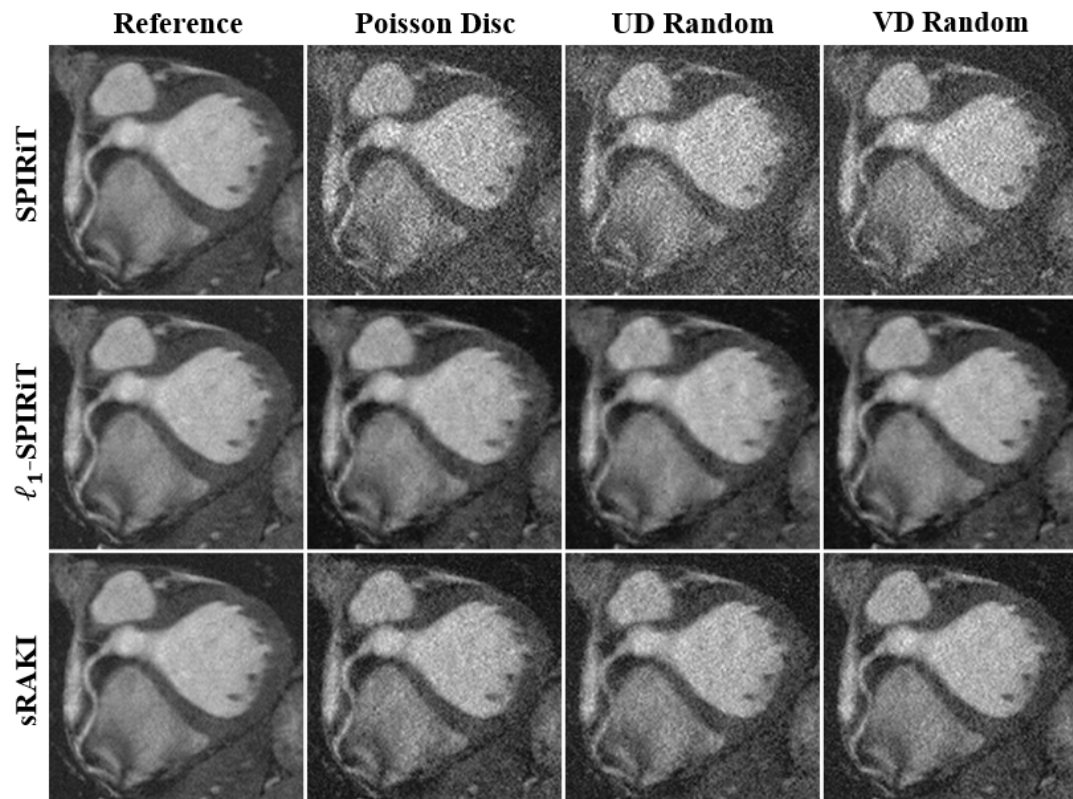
Reformatted right coronary artery (RCA) images from a 3D targeted coronary MRI dataset. The data were retrospectively undersampled with the three different patterns shown in Supporting Figure A.12. These data were then reconstructed using SPIRiT, l_1 -SPIRiT and sRAKI. The results show that sRAKI is more resilient to noise amplification compared with SPIRiT, regardless of undersampling pattern.
